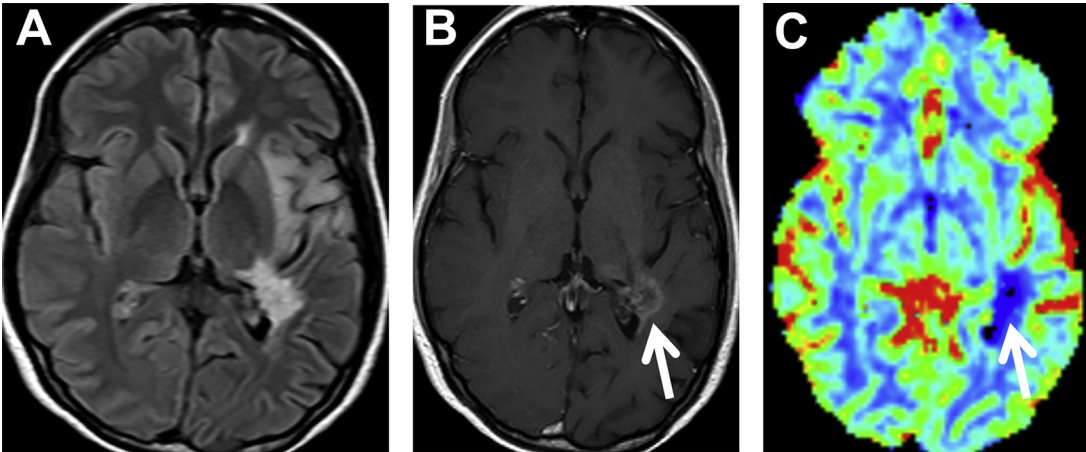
MR imaging performed for surveillance in a 56-year-old man with previously resected and radiated oligoastrocytoma in the left temporal lobe (arrows) reveals new asymmetric FLAIR hyperintensity (A) and ring enhancement (B) within the left peritumoral white matter. Although this could represent either radiation necrosis or recurrent tumor, the lack of increased rCBV on perfusion CBV map (C) favors the former as the likely diagnosis. This lesion was biopsied and was consistent with radiation-induced changes with no neoplastic cells.
